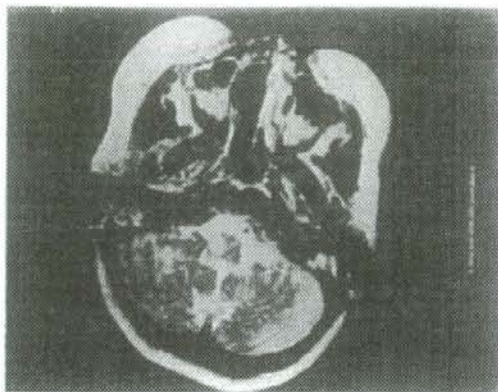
High signal intensity in the right occipital lobe, cerebellum and pons (arrow) on T2-weighted magnetic resonance imaging.
